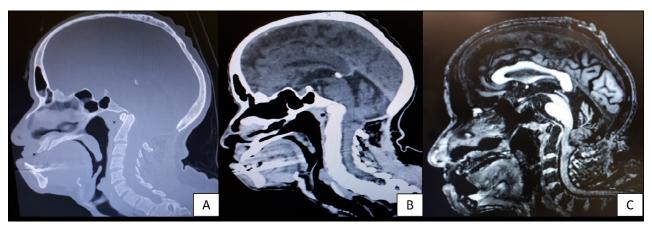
A) SAGITTAL BONE CT SCAN SHOWING CLIVUS HYPOPLASIA, PLATYBASIA, AND A POSTERIOR FOSSA DECOMPRESSION WITH A C1 LAMINECTOMY. B) SAGITTAL SOFT TISSUE CT SCAN SHOWING SOME VENTRAL COMPRESSION OF THE MEDULLA BY THE CLIVUS AND CEREBELLAR ATROPHY. C) SAGITTAL T1 MRI WITH SEVERE CEREBELLAR ATROPHY. ONCE THE PATIENT HAD ONLY ATAXIA ATTRIBUTED TO THE CEREBELLAR DEGENERATION, WE DID NOT INDICATE A NEW SURGICAL PROCEDURE.
